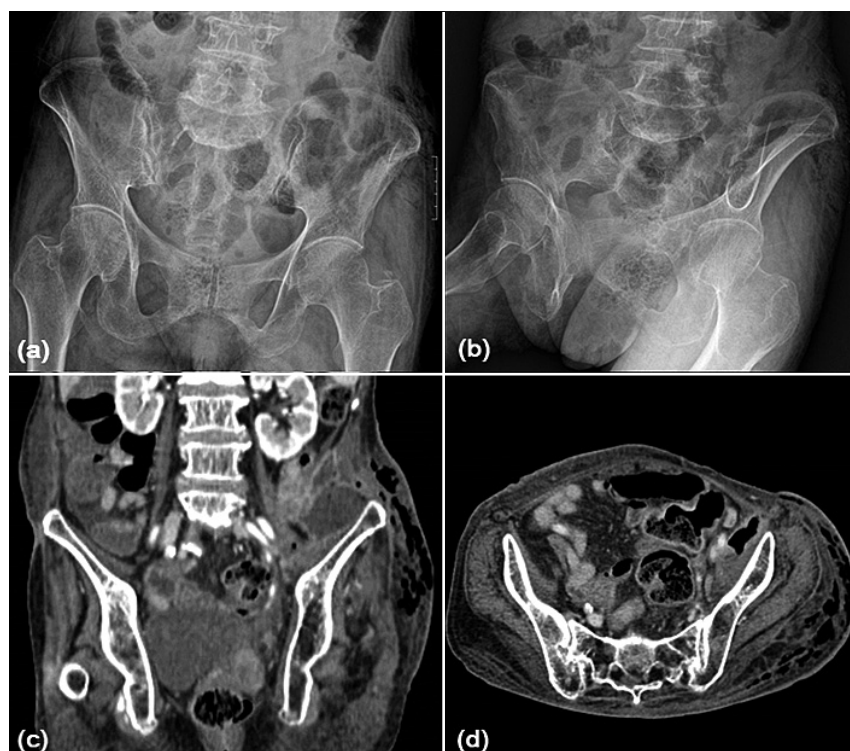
Expired 68-year-old woman with necrotizing fasciitis and history of remote chemo-therapy with surgery due to sigmoid cancer. The time from onset of illness to surgery was 3 days. AP (a), internal oblique (b) radiograph and coronal (c) and axial (d) CT images of hip and pelvis show dermal thickening, fascial edema and gas tracking along superficial and deep fascial planes, consistent with necrotizing fasciitis.
